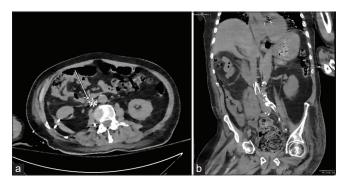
A 74-year-old male who presented with respiratory distress and altered mental status secondary to urosepsis. (a) Axial view on non-contrast computed tomography (CT) image shows the inferior vena cava (IVC) filter (white arrow) within the infrarenal IVC. (b) Coronal view on non-contrast CT image confirms proper placement of the IVC filter within the infrarenal IVC.
